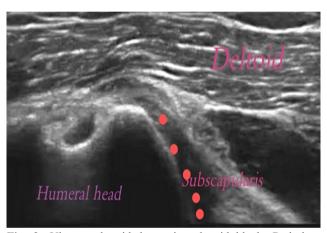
Ultrasound guided anterior glenoid block. Red dots indicate the trajectory of the local anesthetic solution.
